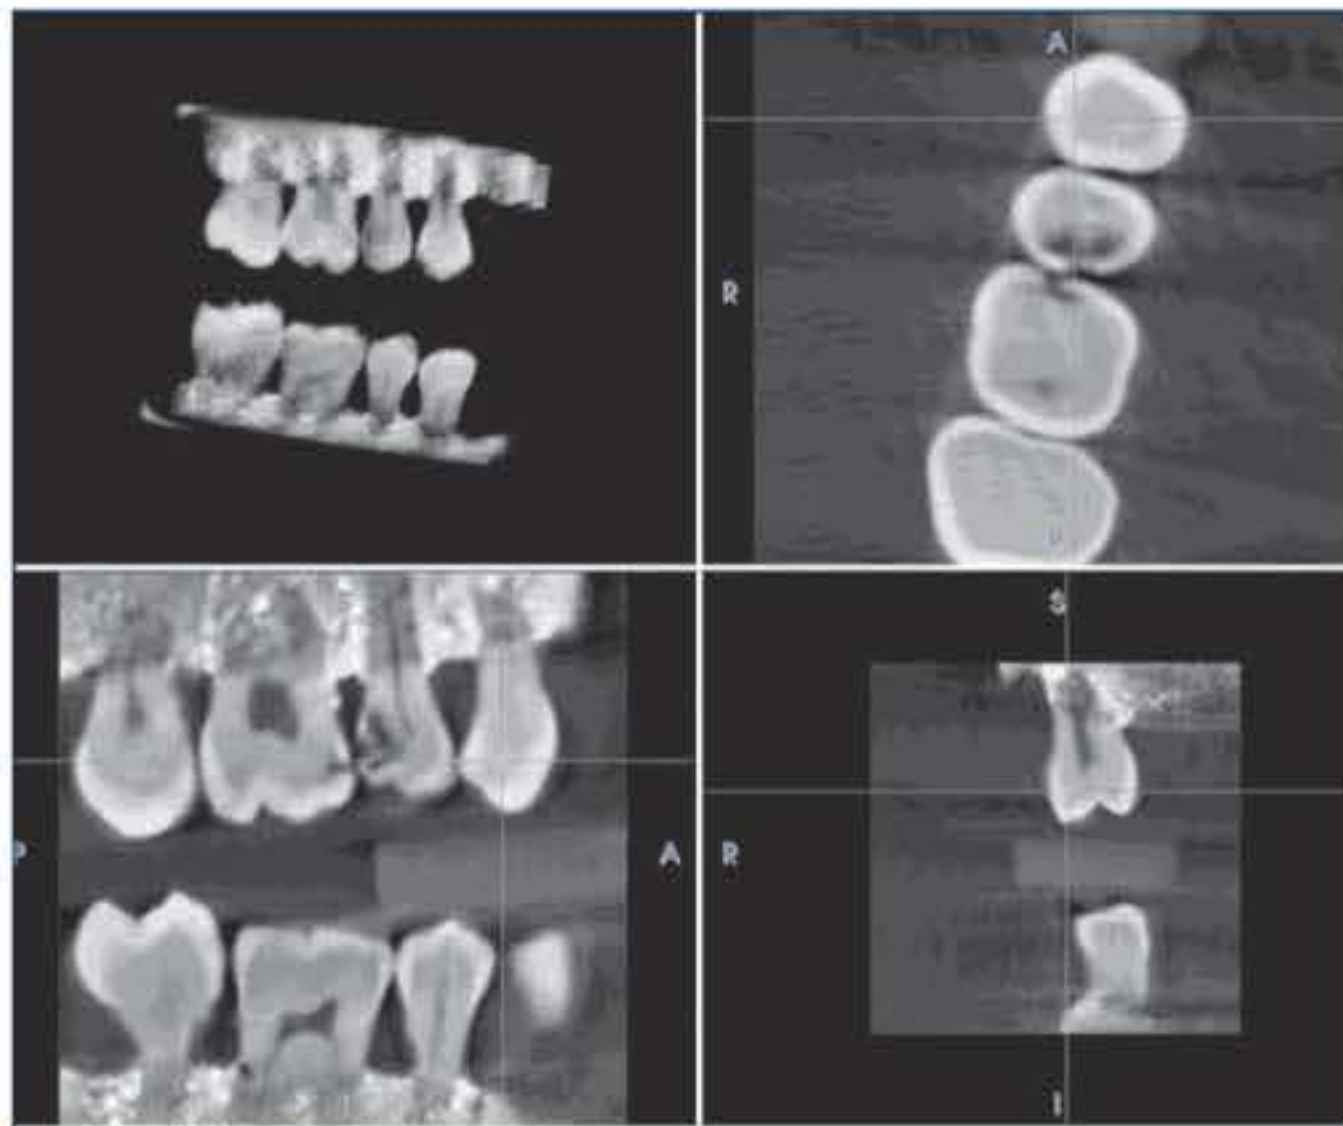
Compared with digital intraoral radiography, the radiolucencies of the carious lesions in teeth 15 and 16 as well as tooth surface discontinuities are clearly discernible in the slice image produced by CBVI.
